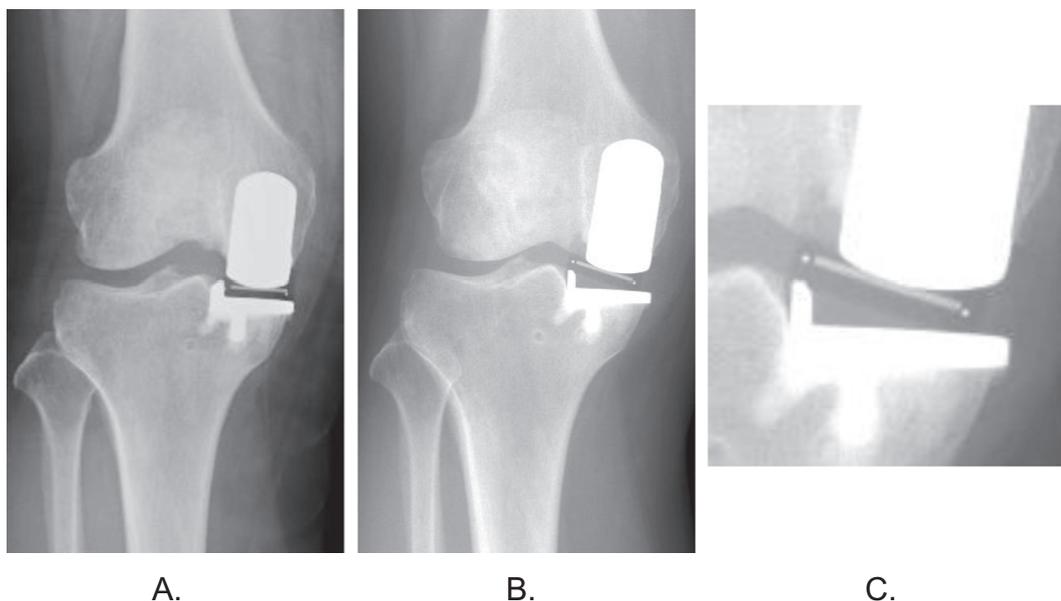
Case 2 radiographs. (A) Postoperative plain radiographs of the right knee (anteroposterior view); (B) plain radiographs when the bearing dislocated into the intercondylar ridge; (C) enlarged radiographs of the bearing with bearing dislocation into the intercondylar ridge.
